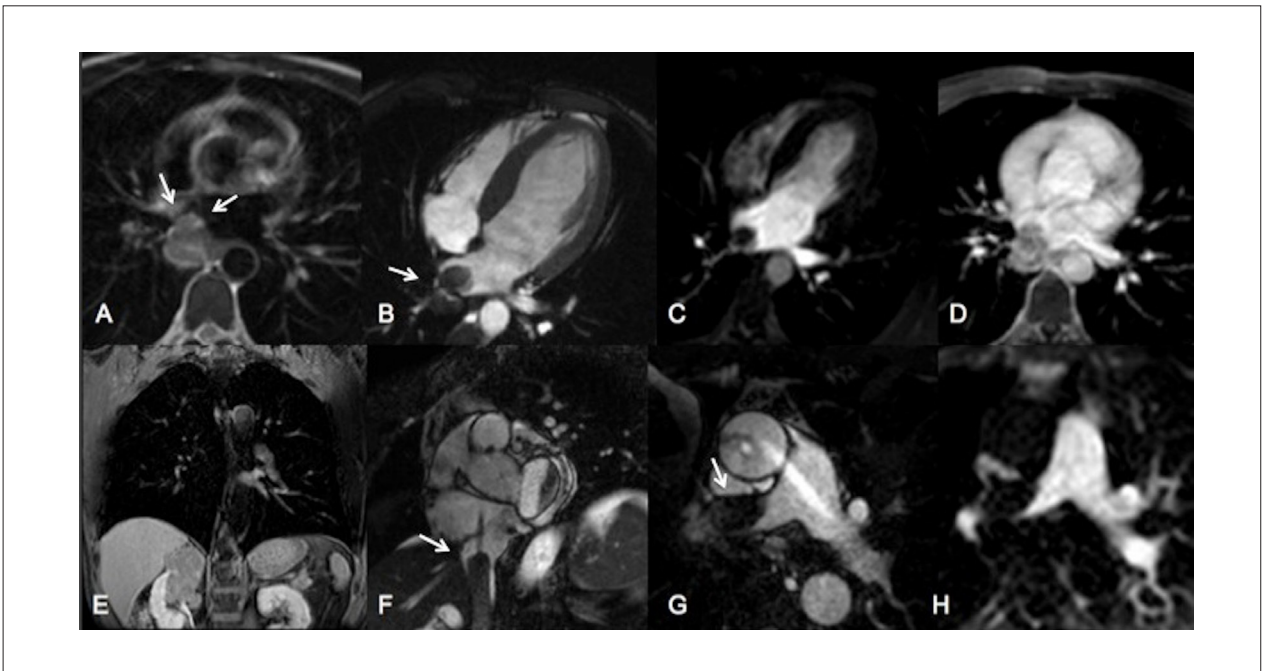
Undifferentiated cardiac sarcoma. Axial T2-weighted sequence (A), SSFP sequences in four-chambers (B) and short axis (C), sequence of LGE in the short axis (D).
